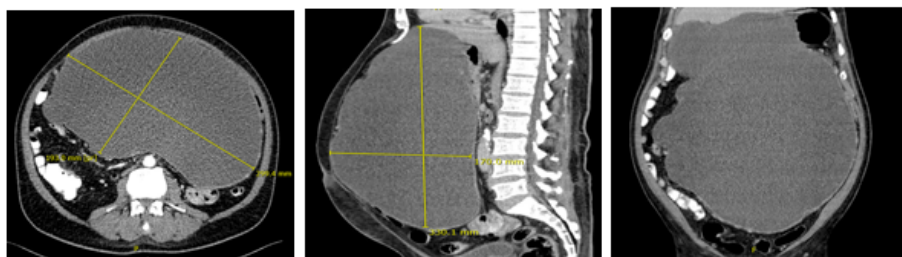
CT abdomen post treatment.
